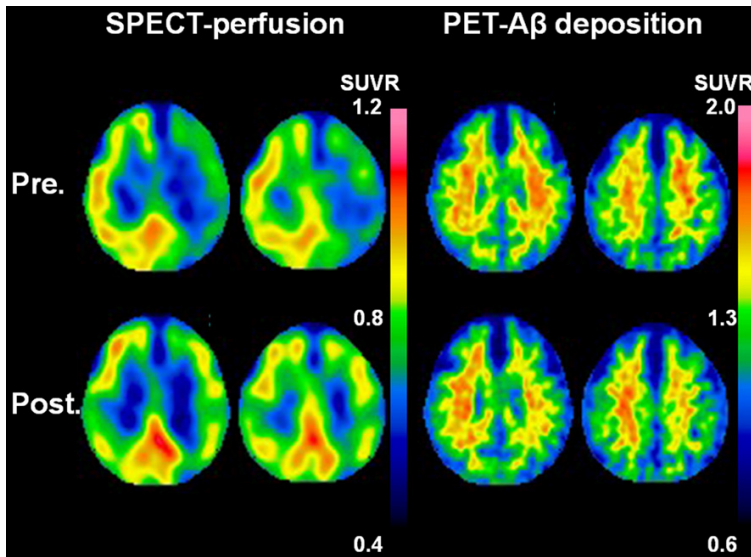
Brain perfusion single-photon emission computed tomography (SPECT) and amyloid β ($A\beta$) deposition positron emission tomography (PET) images in Case 2. Perfusion was preoperatively (pre.) reduced in the left cerebral hemisphere compared with the right cerebral hemisphere (upper), and this reduction was corrected after surgery (lower). $A\beta$ deposition appeared similar between the bilateral cerebral hemispheres before surgery (upper) and was postoperatively (post.) reduced in the left cerebral hemisphere compared with the right cerebral hemisphere (lower). Color scale bars denote standardized uptake value ratio (SUVR) relative to a mean value of bilateral cerebellar hemispheres.
